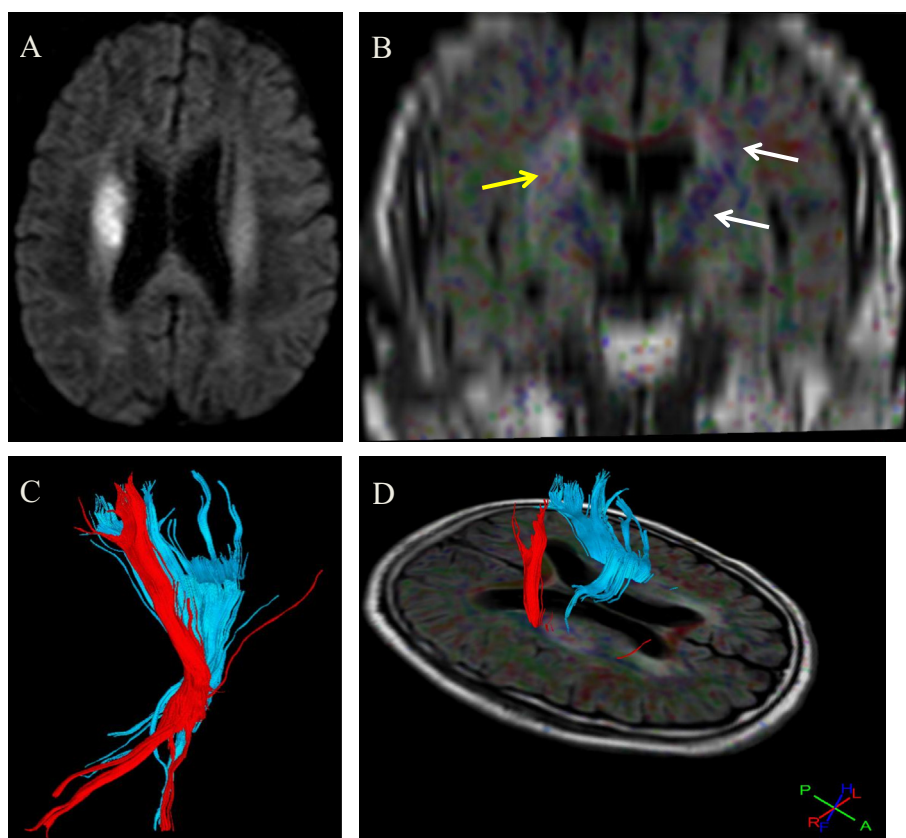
(A) Axial diffusion WIs (b1000) in a 64 years old male presented with left hemiplegia shows right corona radiata area of restricted diffusion (acute infarct). (B) Coronal FA color coded map overlaid over coronal FLAIR image. (C) 3D fiber tractography of the CST. (D) Axial FA color coded map overlaid over axial FLAIR image with 3D tractography of the CST showing disrupted anterior fibers of the corona radiata (yellow arrow) compared to the left side (white arrow). Patient showed mild clinical improvement with residual neurological deficit (NIHSS after 3 months was 4).
